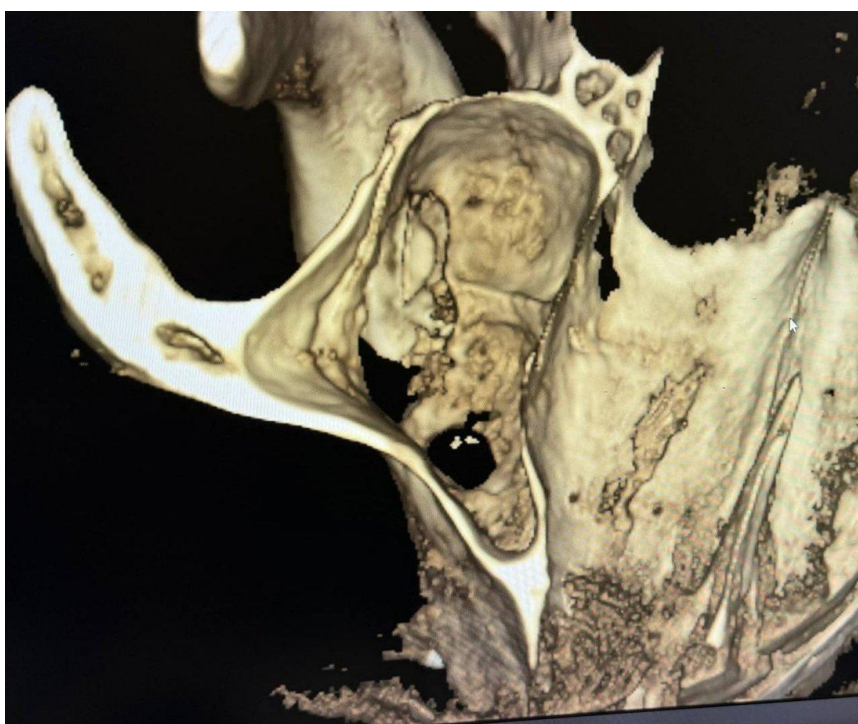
Three-dimensional volume-rendered CBCT reconstruction of the maxilla, showing the antral region and the bony window used to plan surgical access.
